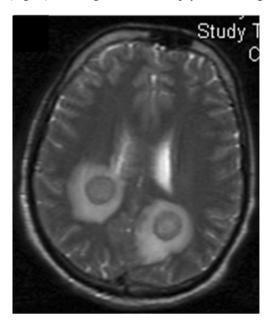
T2-weighted, gadolinium-contrasted MRI of the brain revealing two 2.0 cm ring-enhancing lesions in the parieto-occipital cortex bilaterally with associated vasogenic edema.
